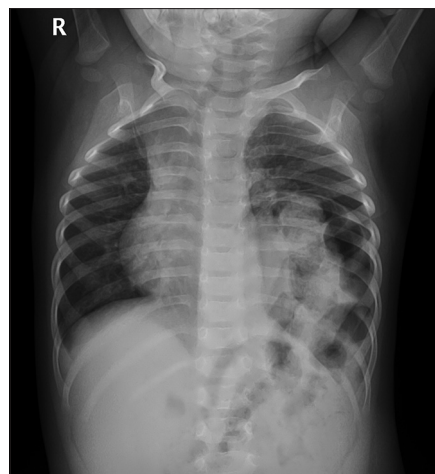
Chest X-ray PA view shows (i) herniated bowel loops in left hemithorax (ii) hemidiaphragm (left) is not separately seen (iii) tracheal and mediastinum are shifted to the right (iv) lung fields are clear (v) no associated pleural effusion seen
